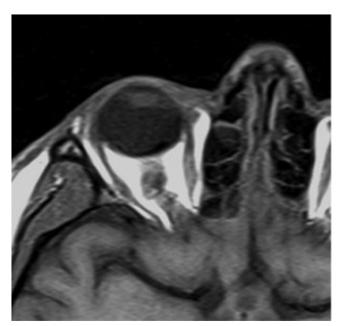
Axial T1-W1. Transverse section of the orbit showing ONT in an astronaut postflight. MRI image provided by the Lifetime Surveillance of Astronaut Health (LSAH) Program, NASA Johnson Space Center.
